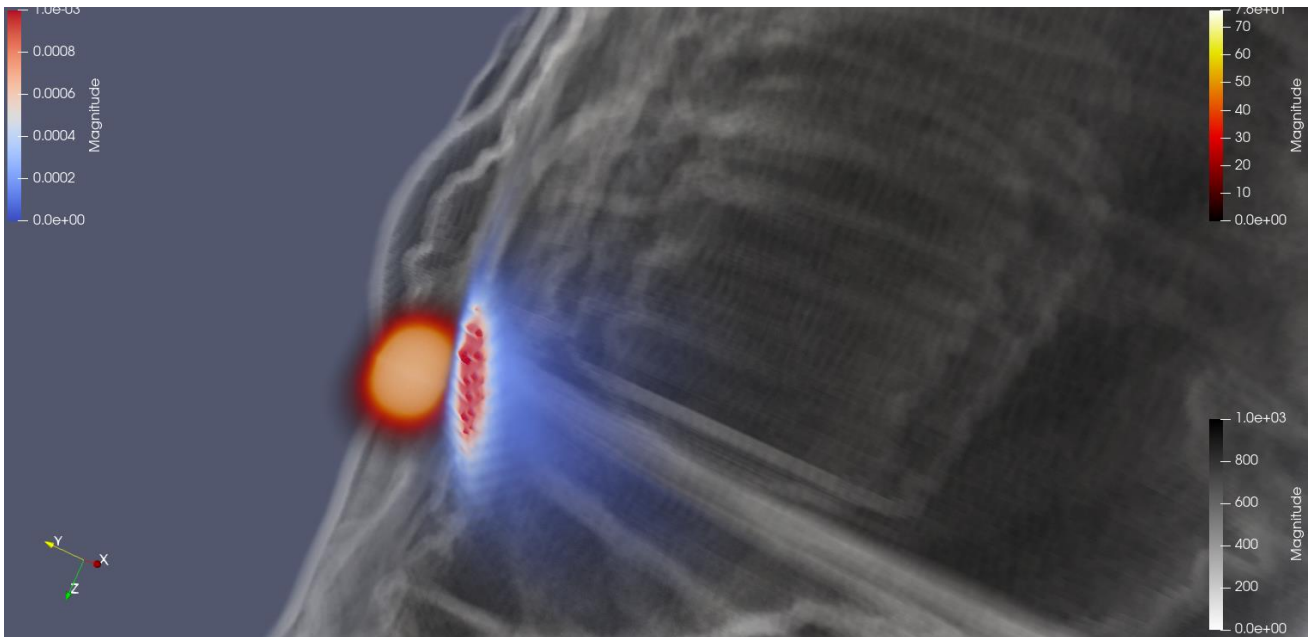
X-ray visualization of the generated electric field magnitude of the embedded antenna: body colour range between [0 – 1000] in x-ray colour pre-set and “shade” option and generated field colour range between [0 – 50] in body-black radiation pre-set.
